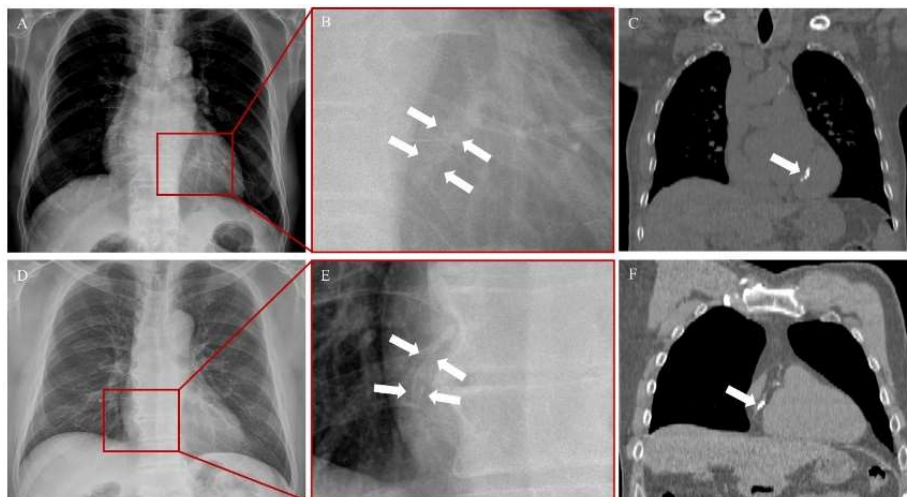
Representative chest X-ray radiographs (CXR) and computed tomography (CT) images of a patients with high coronary artery calcium (CAC) score.
